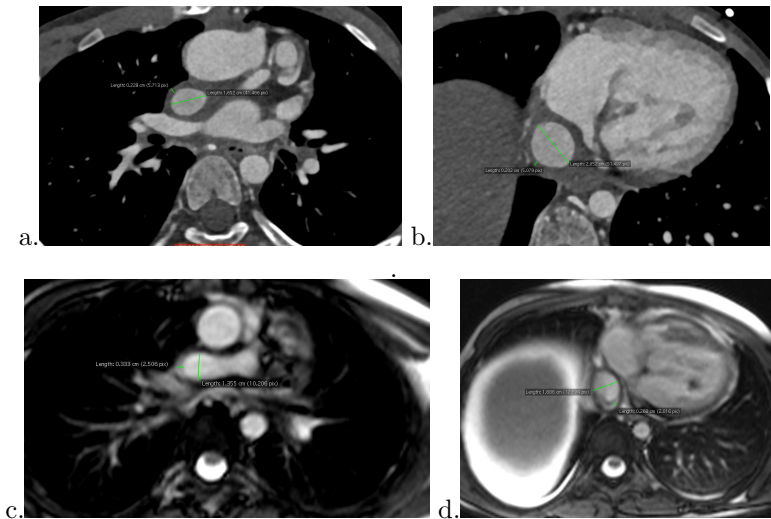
Comparison of CT (a, b) and MR (c, d) scans in the transverse plane of a patient with Fontan circulation. Levels of connection of conduit and SVC (a, c) or IVC (b, d).
